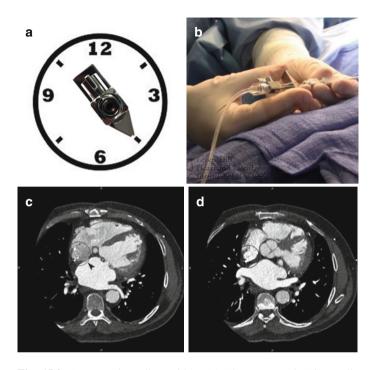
Transseptal needle position. (a) The transseptal (TS) needle indicator arrow dictates the location of the needle tip. With the patient on a horizontal plane (3/9 o'clock), the sheath with sideport and indicator arrow are pointed in the same direction to the 4–5 o'clock location (45° from the horizontal plane). The interatrial septum with the fossa ovalis (FO) is typically a posterior structure located at this position. (b) Holding of the needle and the TS sheath/dilator requires maintaining the same distance from the distal dilator tip (1–2 cm) and concordant movements of the system. (c, d) A clockface superimposed on an axial slice of a cardiac CT reveals the location of the FO at 4–5 o'clock and the aortic valve more anterior at the 1–3 o'clock
